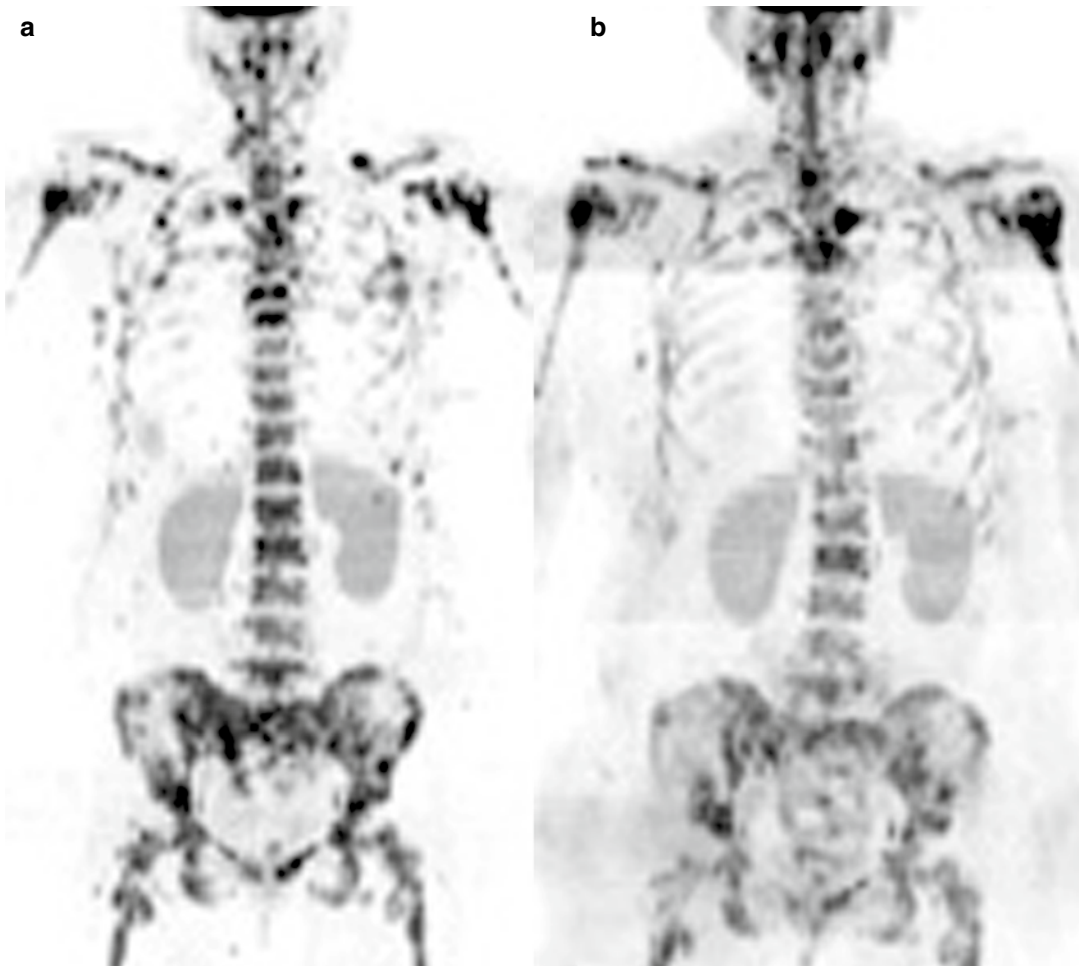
Whole-body diffusion-weighted MR imaging. Inverted greyscale maximum intensity projections (MIPs) of axially acquired DWI from the skull base to mid-thigh level in a patient with metastatic prostate cancer, obtained (a) before and (b) after treatment with a novel
